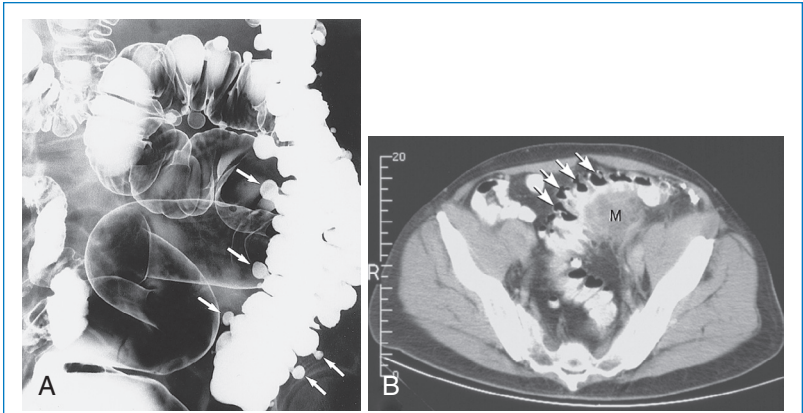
Diverticulosis of the colon is seen on this oblique view of the sigmoid colon (A) during a double-contrast barium enema showing multiple outpouchings (arrows) that represent diverticula. Diverticula also can be seen in a computed tomography scan (B) as outpouchings (arrows), but a developing focal inflammatory mass (M) also is compatible with a developing abscess. (From Mettler FA Jr. *Essentials of radiology*. 2nd ed. Philadelphia: Saunders, 2005, Fig. 6-73.)
